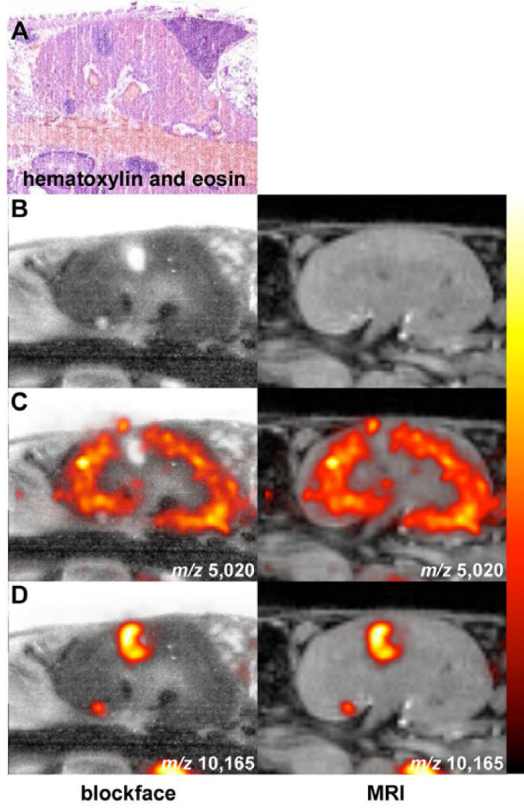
Co-registered MALDI IMS and MRI reveals proteins that exhibit disease state distribution patterns
